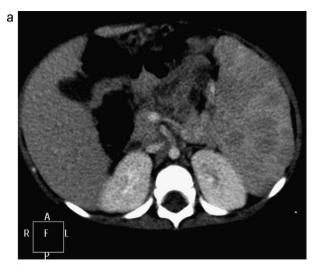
(a) CT-scan of the abdomen, axial plane. Note the numerous hypodense nodules. (b) CT-scan of the abdomen, axial plane. Note the deformation of the splenic contours. (c) CT-scan of the abdomen, coronal plane.
